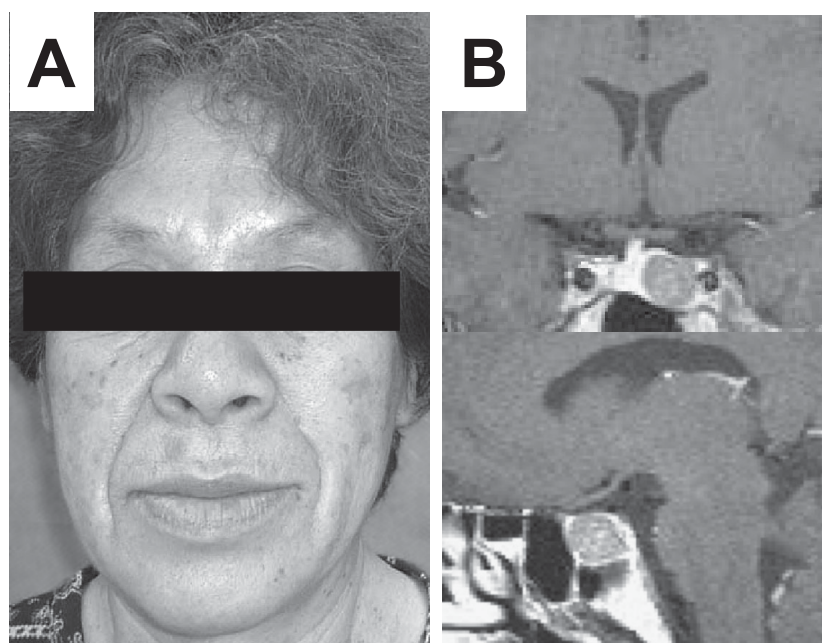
Acromegalic features and pituitary MRI. A) Acromegalic face and B) pituitary MRI of coronal and sagittal views with gadolinium enhancement.
